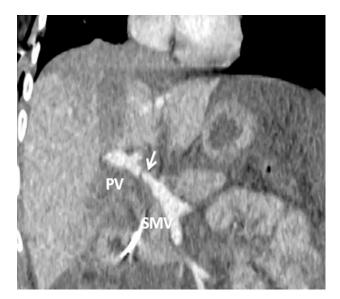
Male patient, 18 years old, 5th day after liver transplantation, computed tomography portovenous phase multiplanar reconstruction, non-occlusive intraluminal filling defect (arrow) in portal vein – non-occlusive portal vein thrombosis. PV - portal vein.
